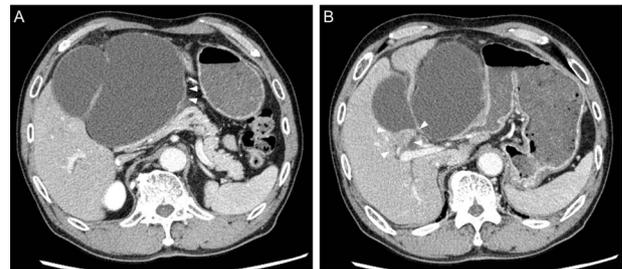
(A) An abdominal computed tomography scan reveals a monolocular cystic lesion in communication with the fundus of the gallbladder. The gallbladder wall thickness remains (arrowheads), while the gallbladder is considerably dilated. (B) An abdominal computed tomography scan reveals a solid and increasingly enhanced mass in the neck of the gallbladder (arrowheads).
